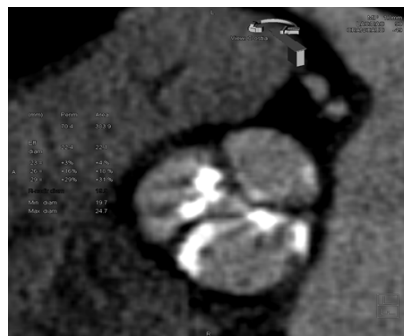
3. CT scan showing calcified AS in tricuspid AV (axial plane)
